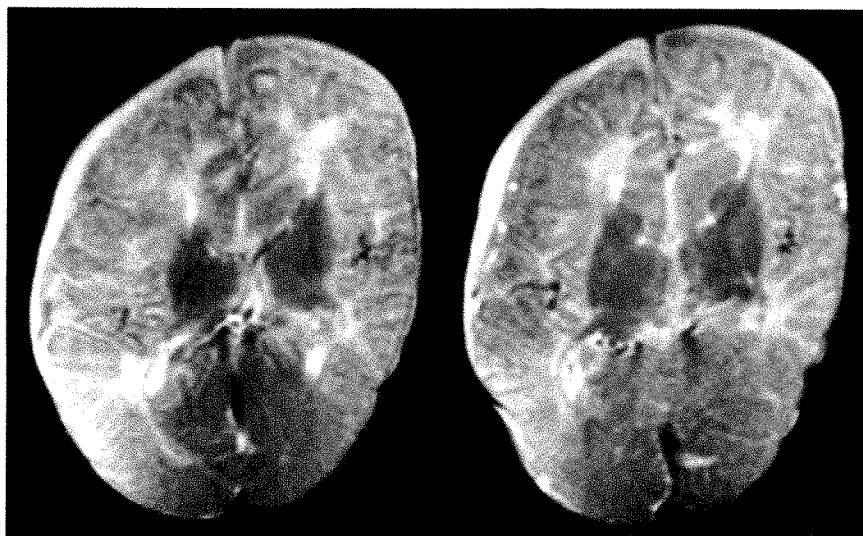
Contiguous 10-mm axial MR images (SE 1900/100) in a 3-month-old boy with marked hypotonia show skull asymmetry and a prominent straight sinus.
